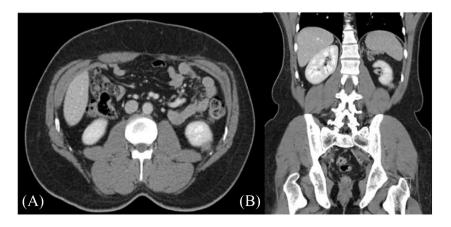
Shows contrast-enhanced CT scan of the abdomen and pelvis with IV contrast in axial (A) and coronal (B) reconstructions, after a year from the last follow-up, demonstrates interval increase in size of focal soft tissue lesion, closely related to the posterior aspect of the left kidney.
